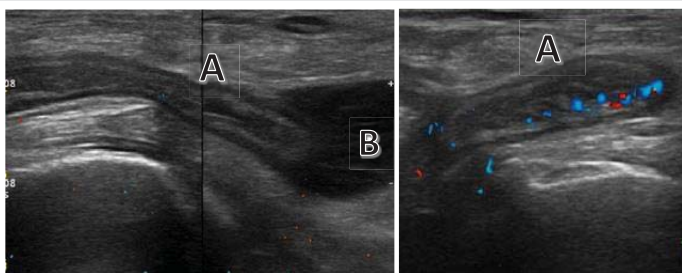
Ultrasound of the right inguinal region: blind digestive structure (A) originating from the cecum (asterisk), vermiform, distended, with a thickened and hyperemic wall on color Doppler, the tip of which is located in the hernia sac, which has a fine echogenic content (B).
